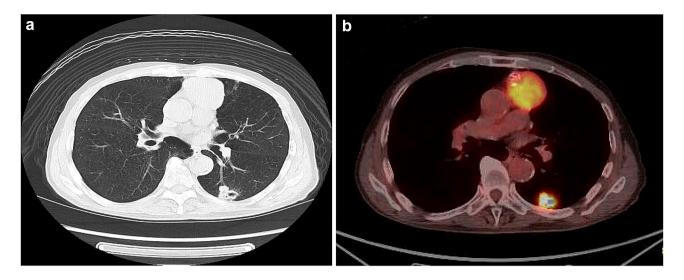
a Lung cancer and thymoma by CT (lung cancer; 35×25 mm, thymoma; 70×45mm). b Lung cancer and thymoma by PET
